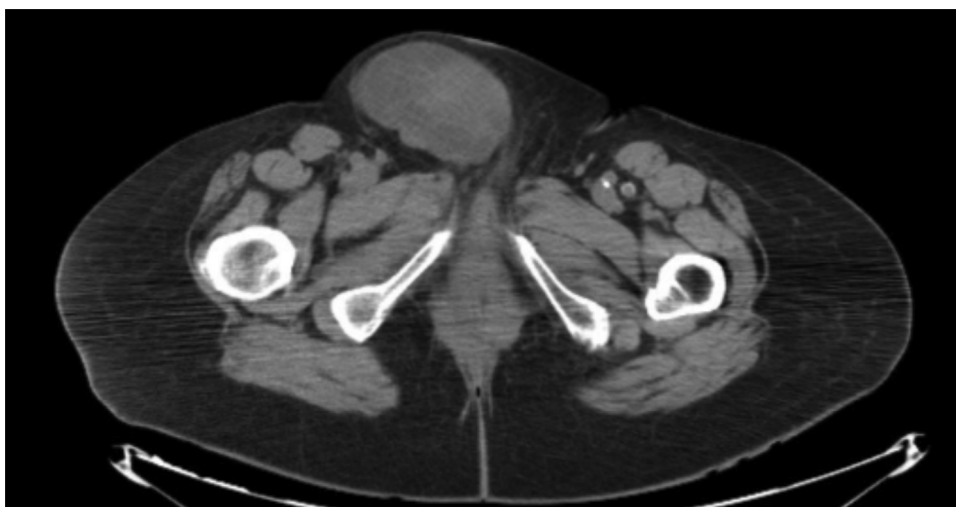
CT image of pelvis showing the lesion in the right groin.
